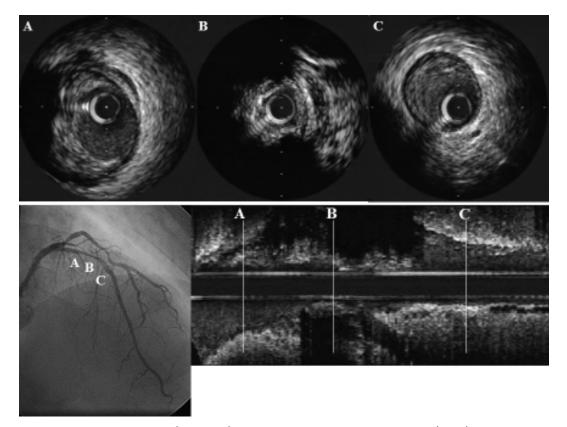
Coronary angiogram (lower left) and intravascular ultrasound images (A-C) prior to directional coronary atherectomy
